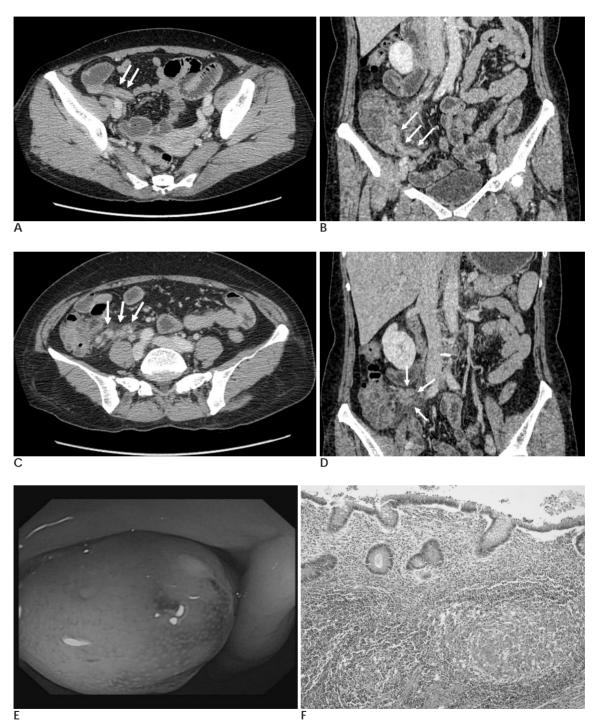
A. A 48-year-old female patient. CT image shows thickening of the appendix with contrast enhancement (arrows). B. A coronal reformatted CT shows the entire length of the thickened appendix (arrows).
